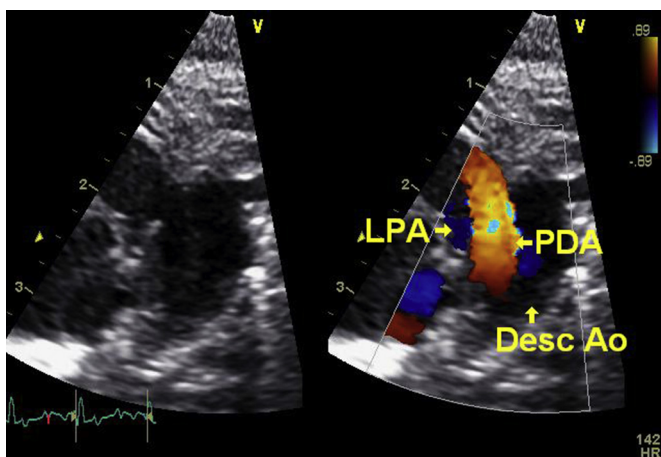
Ultrasound ductal cut with two-dimensional imaging on the left and with color Doppler on the right. This wide-open duct with a mainly left-to-right shunt was found in a preterm baby just a few hours old. LPA, left pulmonary artery; PDA, patent ductus arteriosus; Desc Ao, descending aorta.
